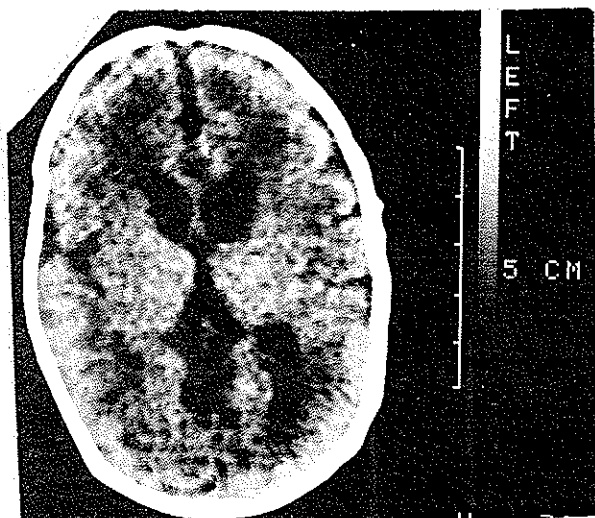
CT scan of SGA asphyxiated patient with prolonged hyperglycemia shows atrophy of cerebral cortex and ex vacuo hydrocephalus
